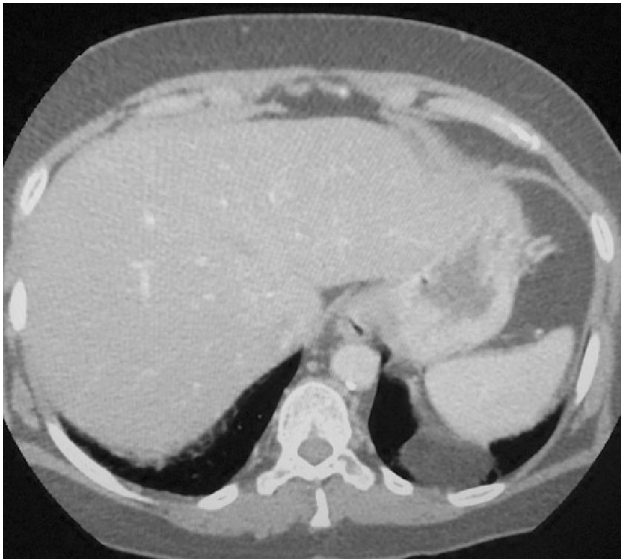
Axial section of CT Scan chest showing a well defined fat attenuation lesion in the postero-lateral aspect of left lower thoracic cavity. It is making obtuse angle with lung parenchyma with tapered edges.
